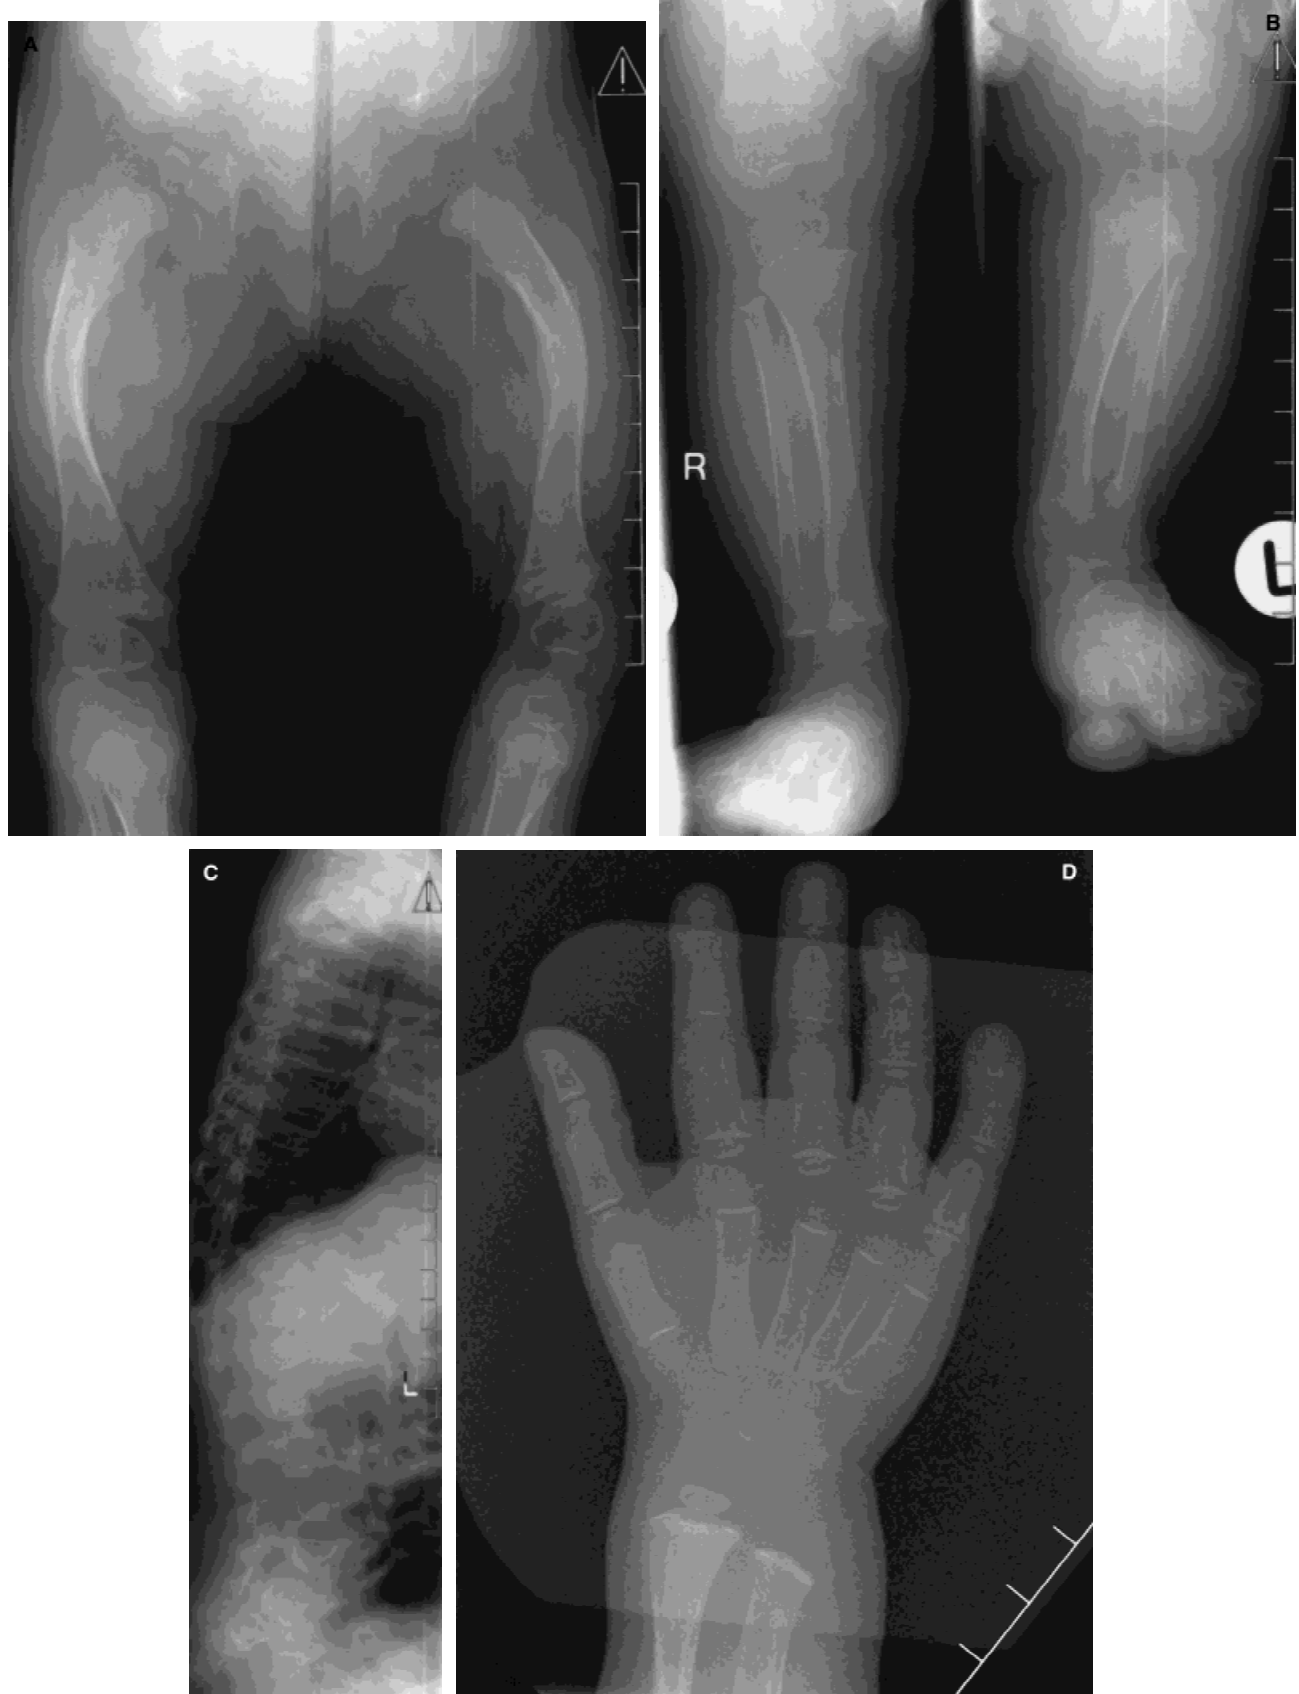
X-ray examination of the legs (A,B) demonstrating irregular widened metaphyses, bowing of the femora, and small compression fracture of the distal left fibula, spine (C) showing marked osteopenia, anterior rounding and minor irregularity of several vertebrae, and hand (D) showing metaphyseal cupping of the distal metacarpals and proximal phalanges .
